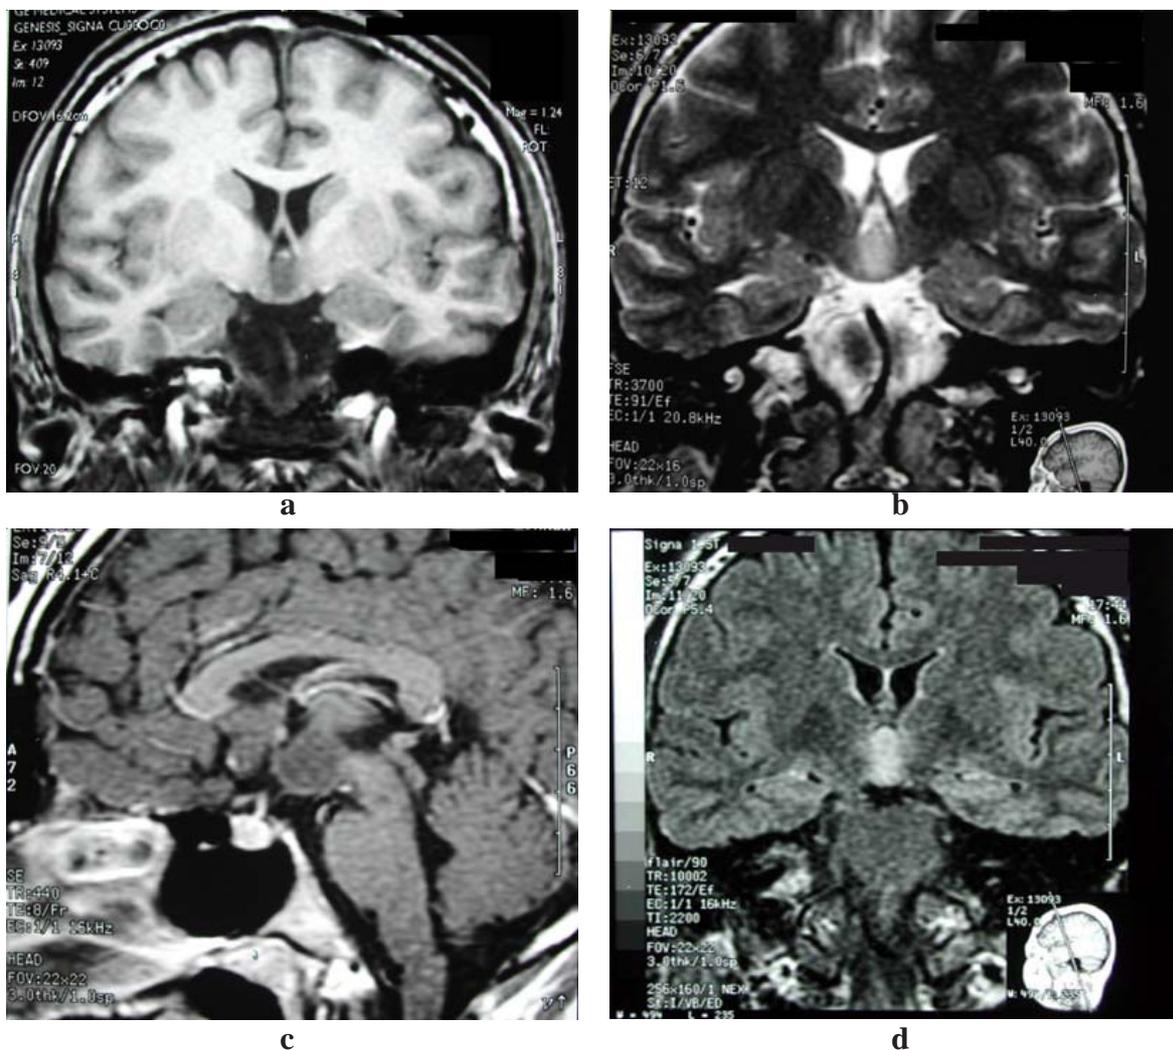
Coronal and sagittal MRI reveal hypothalamic hamartoma in the third ventricle with broad attachment to tuber cinereum
